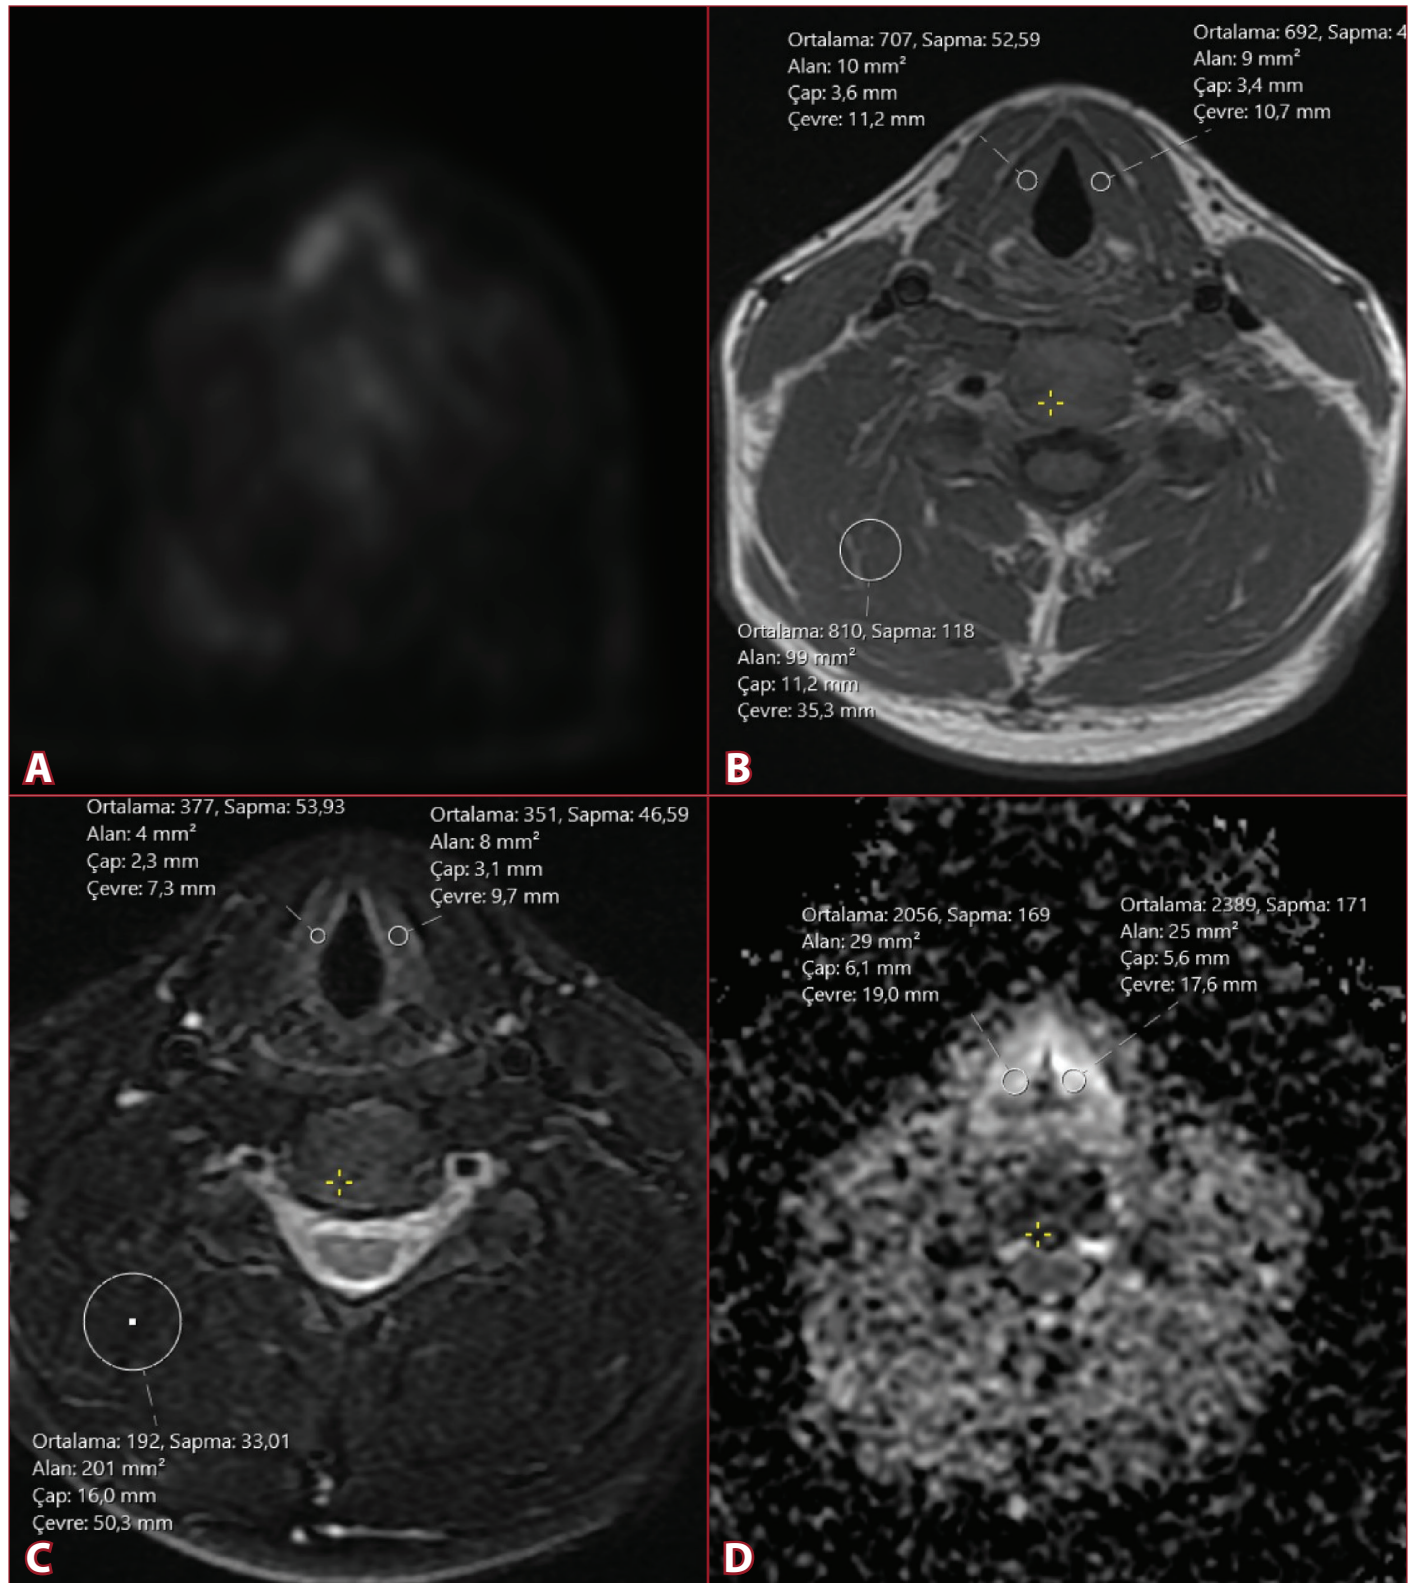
A 35-year-old patient followed with a diagnosis of germ cell tumor showed uptake at the level of the vocal cord on PET imaging. (A) PET image demonstrates focal FDG uptake at the vocal cord level. (B-C) Axial T1-weighted and fat-suppressed T2-weighted images show no pathological signal alteration in the vocal cord. ROI measurements obtained from the vocal cord and paravertebral muscle planes are shown. (D) ADC map demonstrates measurements obtained at the level of the vocal cord.
